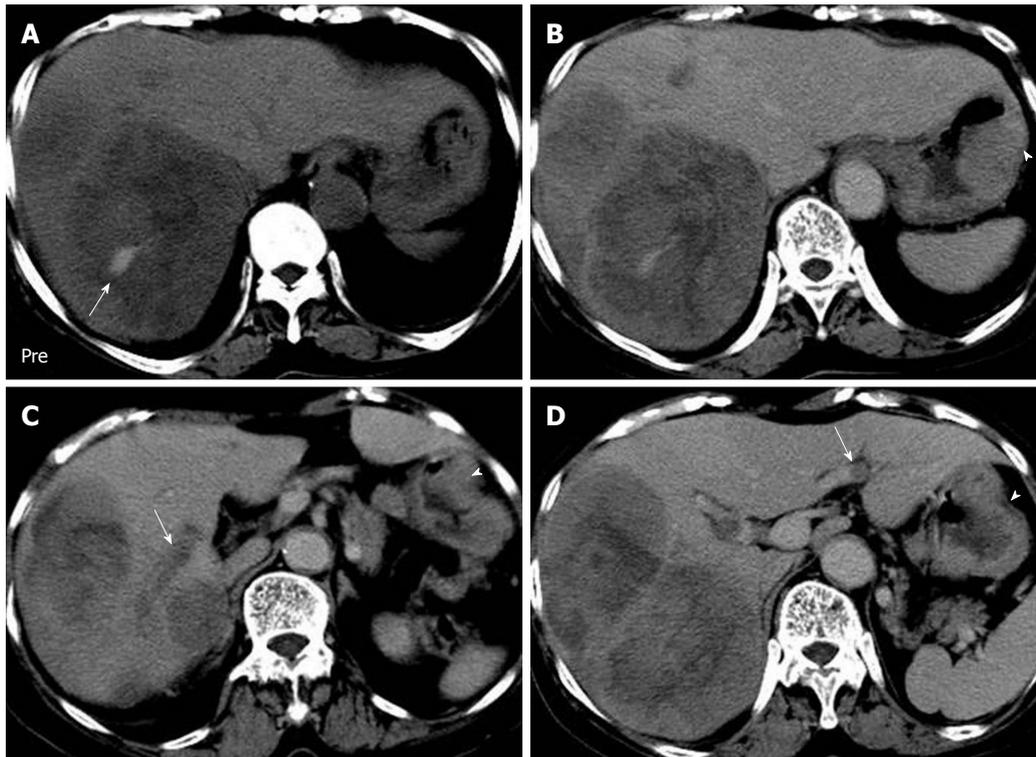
Venous tumor thrombosis in a 69-yr-old female with hepatoid adenocarcinoma of the stomach and liver metastases. A: Bulky liver metastases presented with tumor hemorrhage (arrow) on precontrast computed tomography; B and C: Eccentric wall thickening and heterogenous enhancement of the gastric body (arrowheads) implied gastric malignancy. On portal venous phase, the liver mass presented irregular central necrosis (B) and right portal vein tumor thrombosis (arrow; C); D: Isolated left portal vein tumor thrombosis (arrow) was observed. No visible liver nodule was found at the left liver lobe. Pre: Precontrast.
